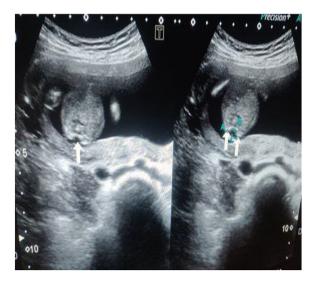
Axial B-mode ultrasound image of back showing presence of only 1 vertebral column with herniation of small amount of CSF and brain tissue via defect in posterior element in lower lumbar levels suggestive of small meningomyelocele (marked by white arrows).
